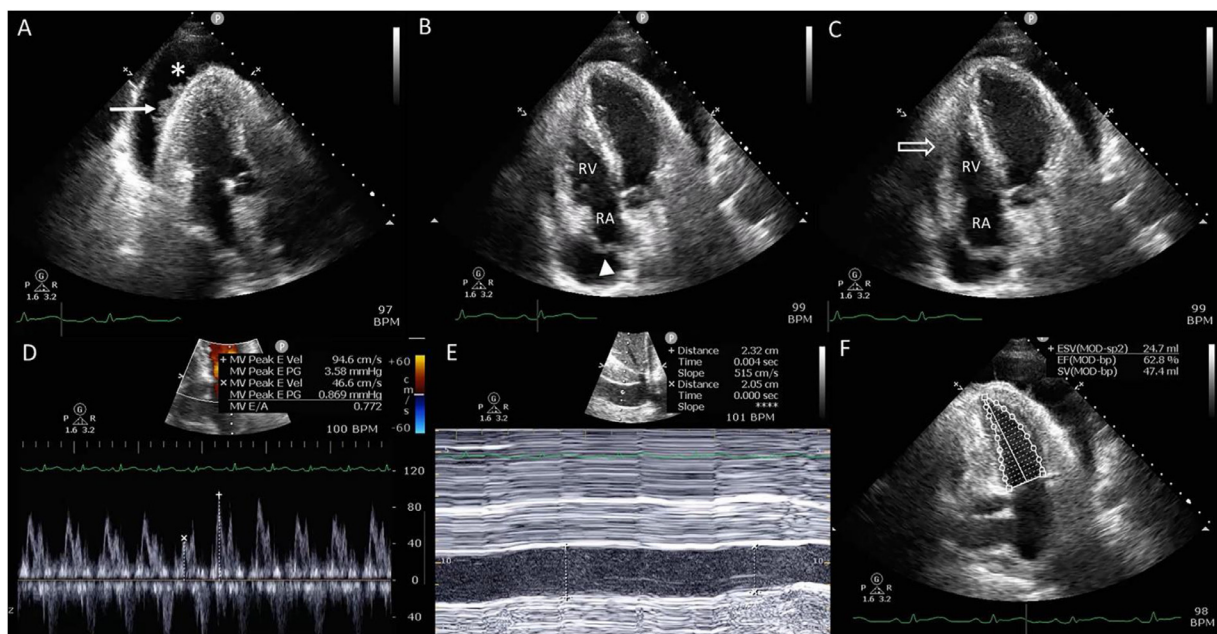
(A) Transthoracic echocardiography demonstrated a large amount of pericardial effusion (asterisk) with frond-like hyperechoic projections from the surface of pericardium (arrow). (B and C) The collapsed RA in diastole (arrowhead) and the collapsed RV in the early diastolic phase (open arrow). (D) The mitral valve (MV) inflow velocity measurement depicted more than 25% respiratory variation in mitral inflow. (E) IVC imaged in M-mode demonstrated a lack of the normal inspiratory collapse of a dilated IVC, indicating IVC plethora. (F) Left ventricle ejection fraction assessment using Simpson's biplane method. The LVEF is about 62.8%.
